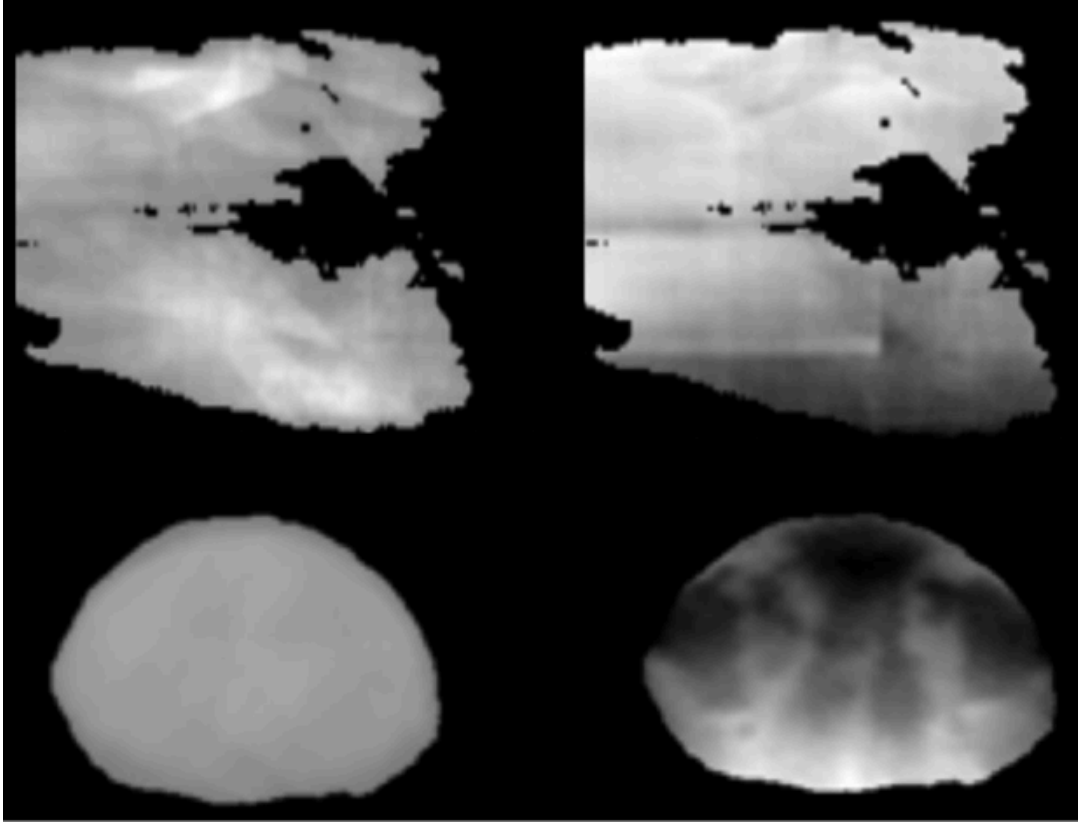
Reconstruction criteria. (Top row) a typical clinical plan that cannot be used for VMAT-CT reconstruction, its masking function (top left) and the reconstruction result (top right). (Bottom row) a typical clinical plan that can be used for VMAT-CT reconstruction, its masking function (bottom left) and the reconstruction result (bottom right).
